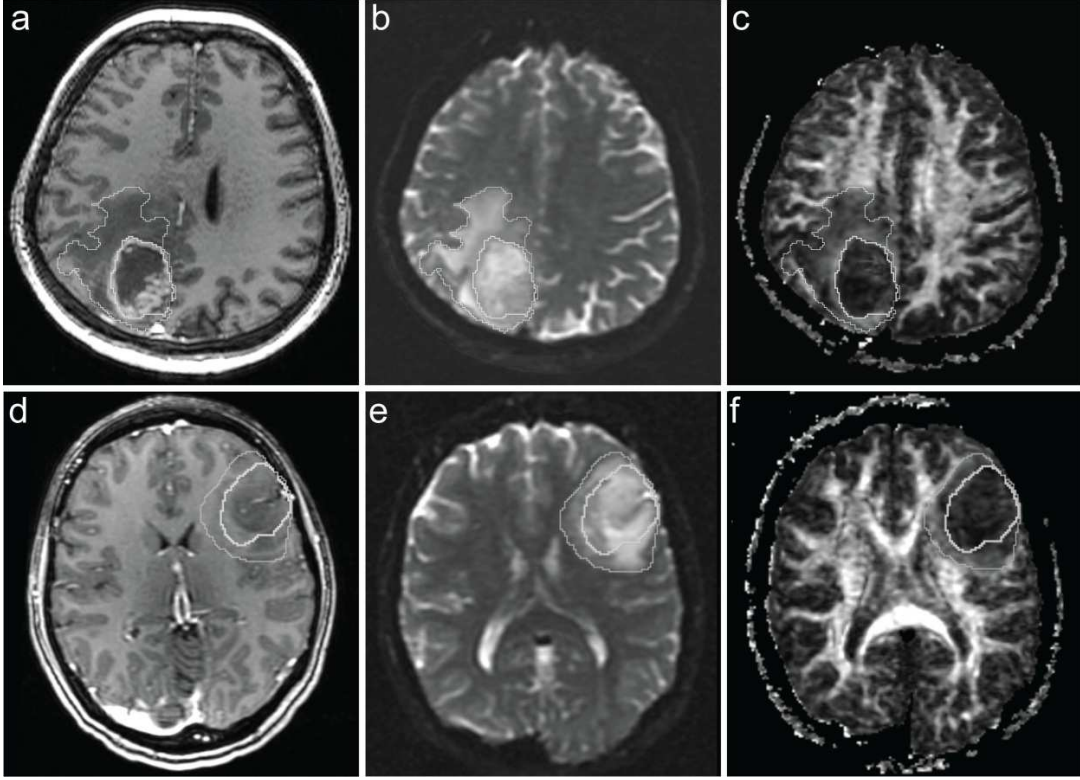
Outlining tumors on B_0 and fractional anisotropy images. First row shows axial images of a patient with GBM while the second row presents a typical case on a non-enhancing low grade glioma. Tumor regions were manually drawn on DTI parametric maps. White border delineates the following two areas: high intensity abnormal region on B_0 images (outside) and low intensity abnormal region on FA maps (inside). (a) and (d): postcontrast T1-weighted; (b), (e): B_0 image; (c), (f): fractional anisotropy map.
